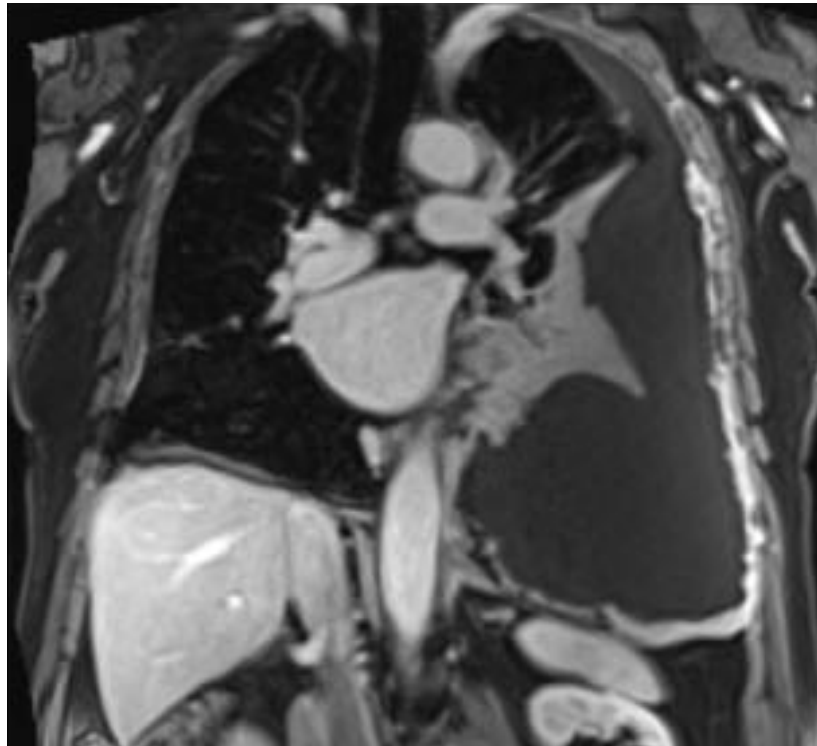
T1-weighted coronal image of a patient with a large malignant pleural effusion and inverted left hemi-diaphragm, taken post-contrast using a 3T Siemens Magnetom PRISMA® MR scanner at the Glasgow Clinical Research Imaging Facility, QEUH
